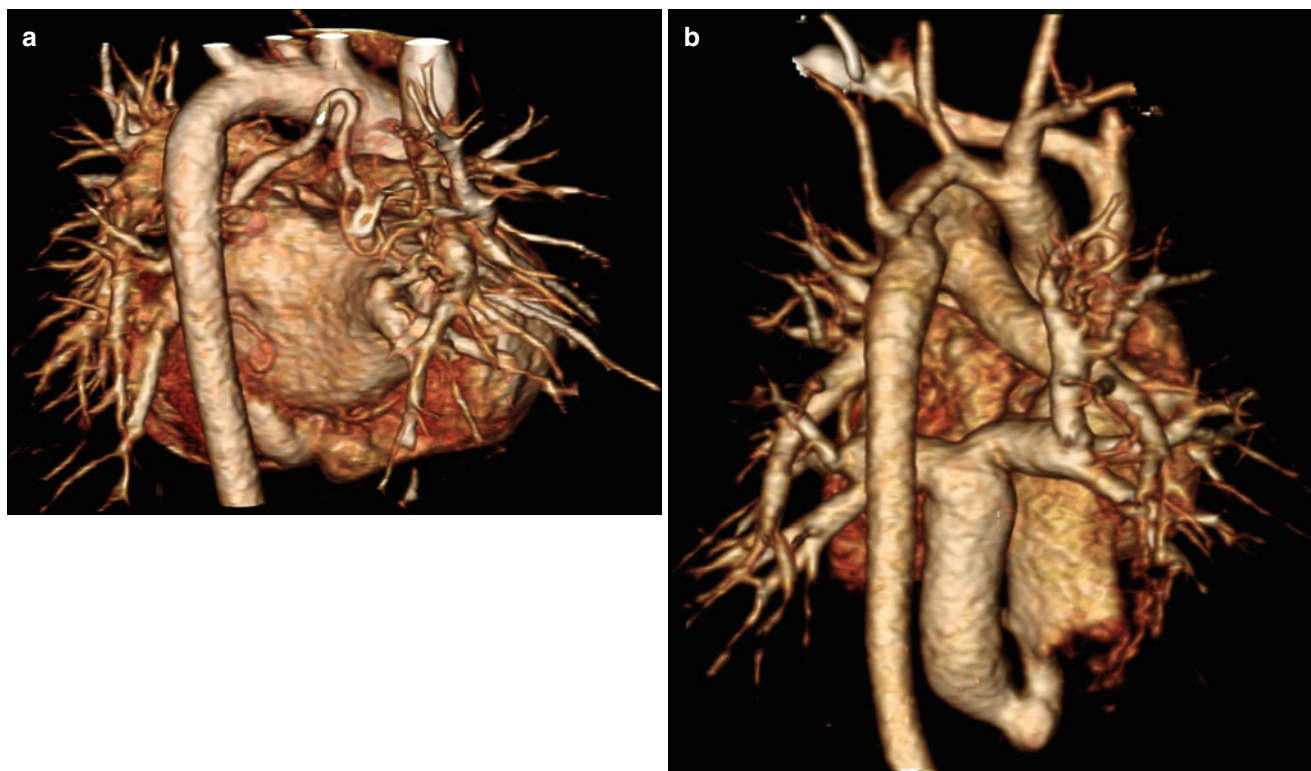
Scan range for cardiac CT. Scan range is one of the most important parameters for radiation exposure. The scan range should be kept as short as possible. (a) The optimal scan range for the usual cardiac scan is from just above the aortic arch to just below the diaphragmatic surface. (b) This scan is intentionally done with extended scan
